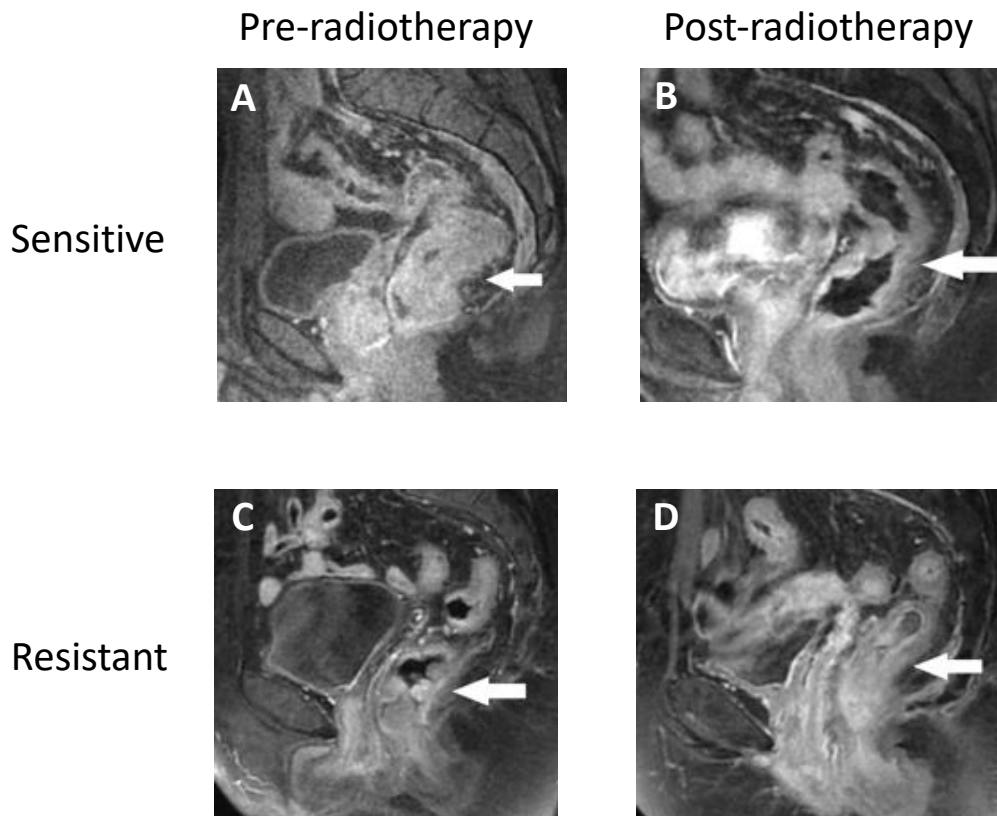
In vitro* treatment predicted the clinical outcomes of rectal cancer patients treated with neo-adjuvant radiation. Representative MRI images before (A) and after (B) the radiotherapy of a patient whose CSCs became sensitive
